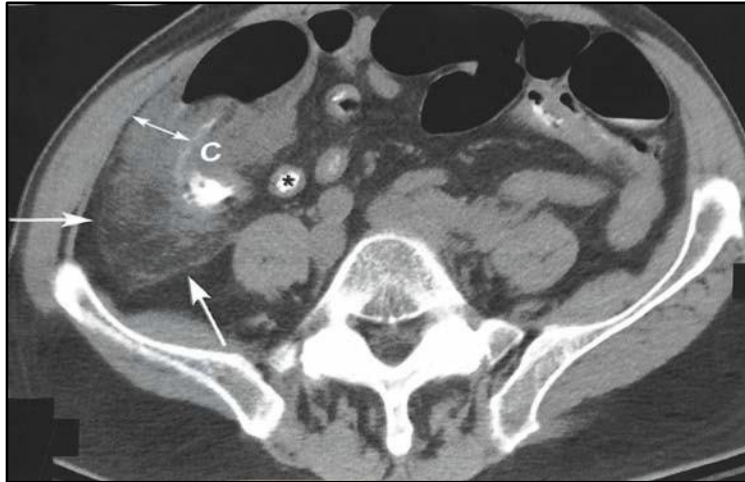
Contrast CT- Showing inflamed Appendix arrows (single headed) pointing to Abscess
